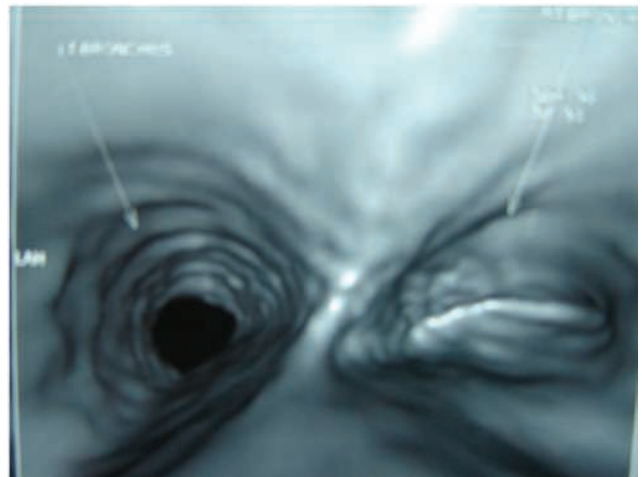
Virtual endoscopic reconstruction from the computed tomography (CT) showing collapsed right bronchus in a patient with injury to the right bronchus (Courtesy: Gupta *et al.* Eur J Trauma Emerg Surg 2012;38:553-61)
